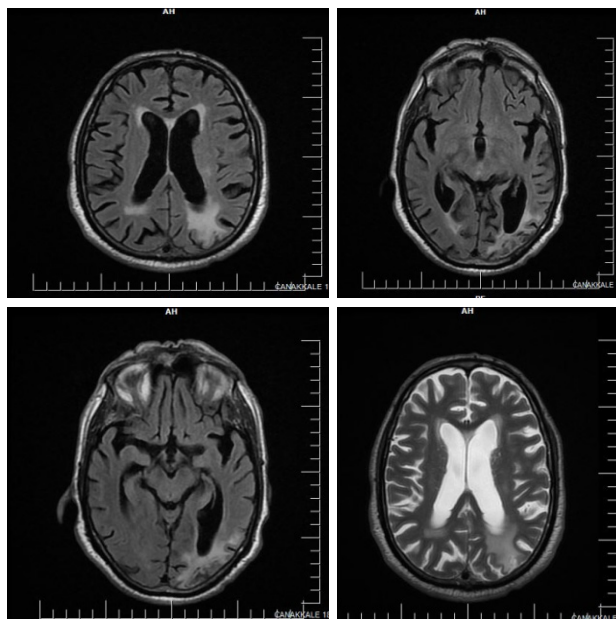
Fluid attenuated inversion recovery (FLAIR) and T2-weighted image images left posterior circulation infarction
